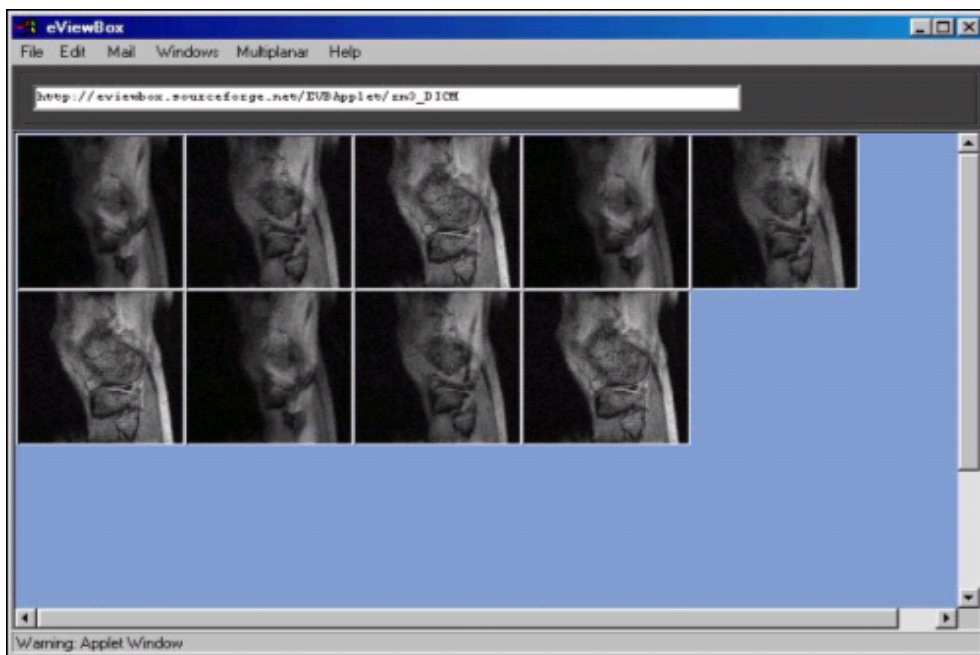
X-ray images opened with DICOM viewer
